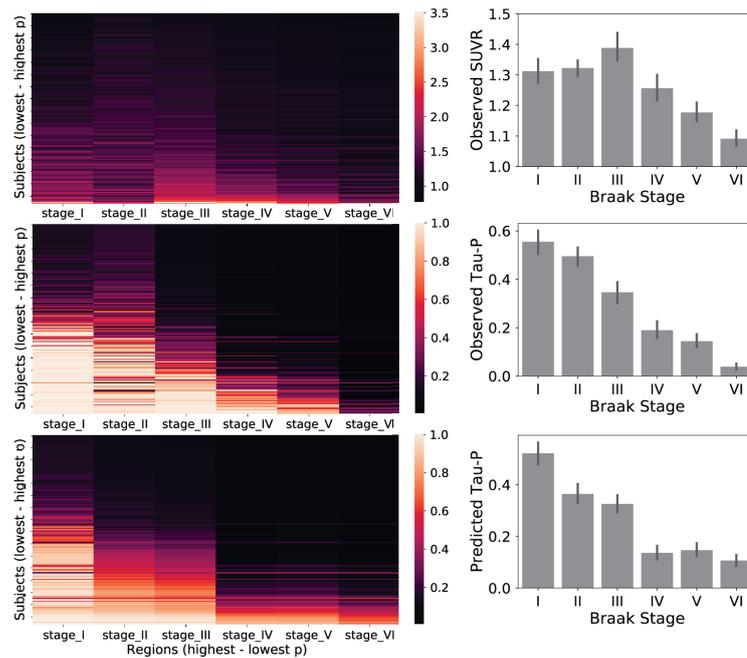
Each brain region was divided into one of six "Braak stage" ROIs, based on which Braak stage abnormal tau is first observed in the region (as described in Schöll et al., 2016b). (Left) Each row is a subject sorted top-bottom by least to most overall tau. Each column is an Braak stage ROI, sorted left to right by most to least overall tau. Warmer colors represent higher SUVR values (top), observed tau-positive probabilities (middle) or predicted tau-positive probabilities from the best-fitting ESM (bottom). (Right) The same relationship shown in a barchart format. Error bars represent standard error of the mean. Conversion to tau-positive probabilities creates a sparse distribution of values demonstrating a progression reminiscent of the staging described in the autopsy literature.
